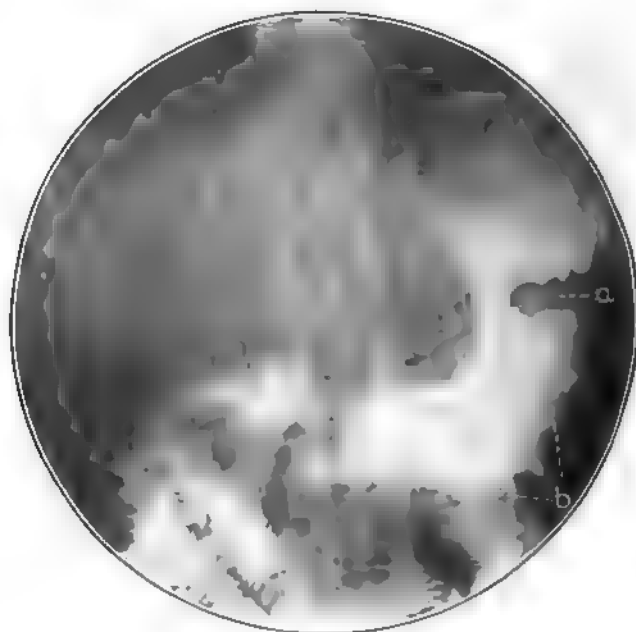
Broad deep incisura, *a*, and extensive spasm throughout greater curvature, *b*. No other roentgen signs. Small cancer, posterior wall, found at operation.
